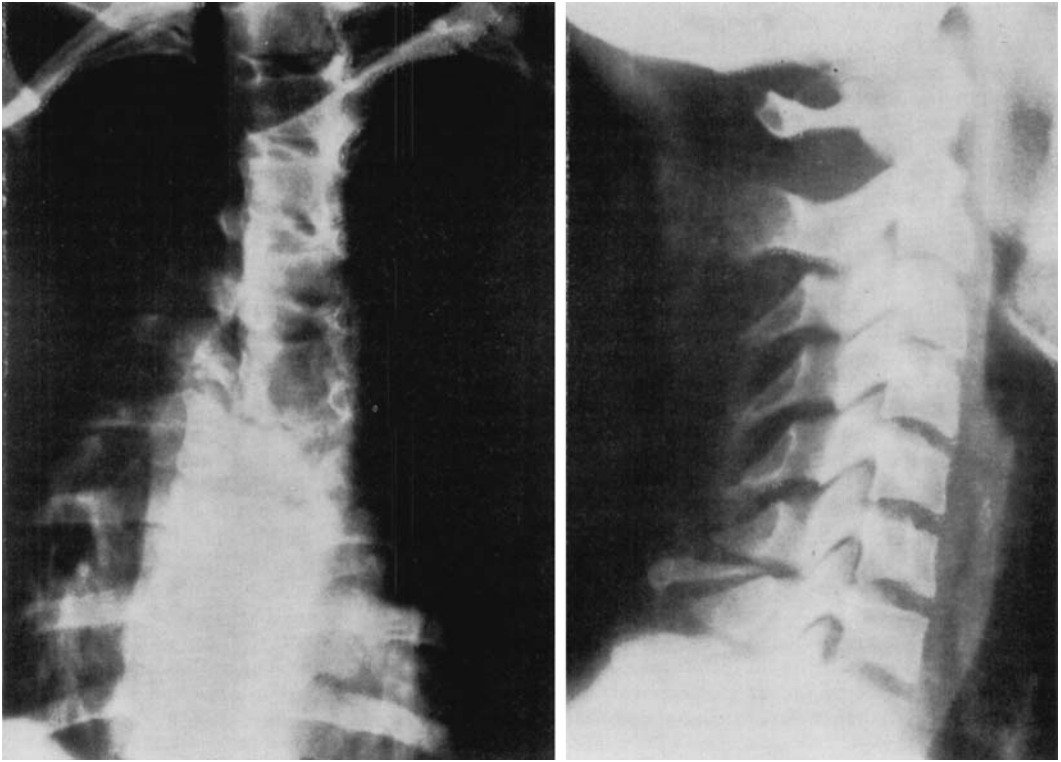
(Case 2). Left—x-ray of thoracic spine, taken at time of admission, reveals fracture dislocation of T_5 , T_6 & T_7 with maximum compression and displacement at T_6 . Right—x-ray of cervical spine, taken at time of admission, reveals fractures of the spinous processes of C_6 and C_7 . The spinous process of T_1 was also fractured but is not visible on this plate.
